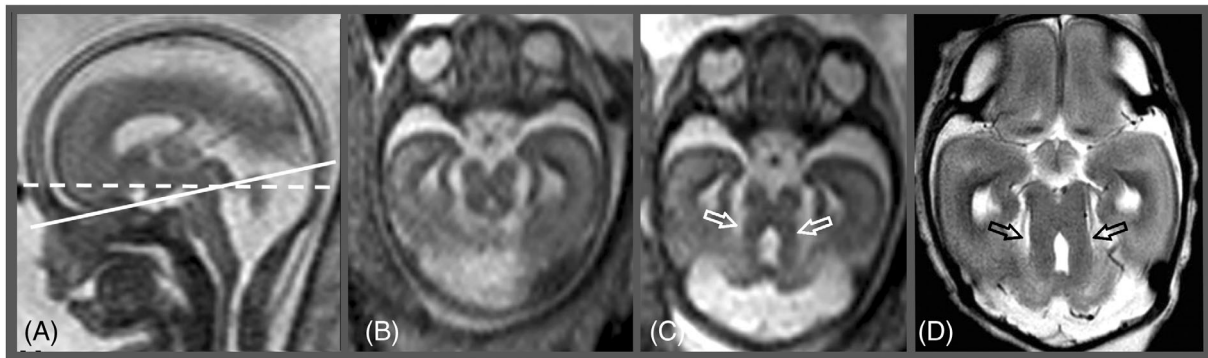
Molar tooth sign, 20 GW. (A) Sagittal T2-weighted image showing hypo-dysplastic vermis and wide communication between the fourth ventricle and the cisterna magna; (B) axial T2-weighted image (plane indicated by the solid line on A) shows misleading, relatively normal appearance of the midbrain; (C) axial T2-weighted image with different angulation (dotted line on A) reveals classical molar tooth sign (arrows), which is confirmed on post-mortem imaging (arrows, D)
